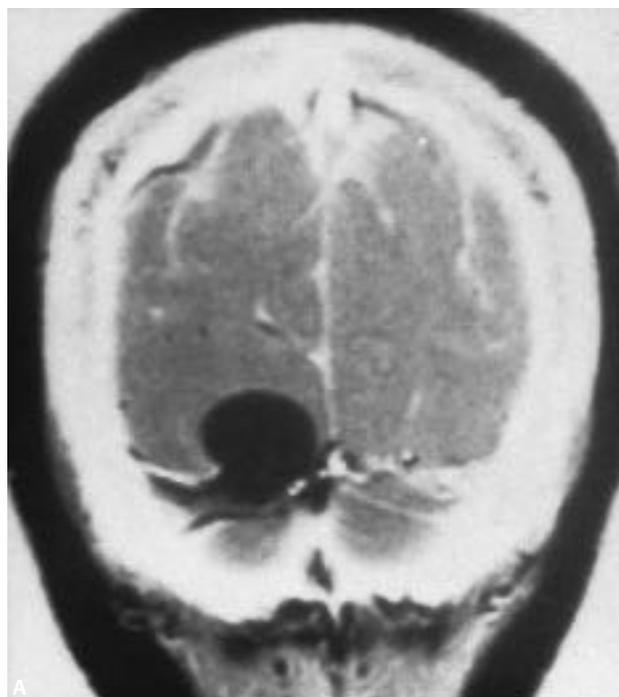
T1-weighted gadolinium-enhanced magnetic resonance image in (A) coronal and (B) parasagittal plane. Multiplanar imaging of peritorcular meningiomas depicts the tumor's relation to the torcular, greatly facilitating the planning of the surgical approach. This peritorcular meningeoma envelopes the right transverse sinus at the torcular.
